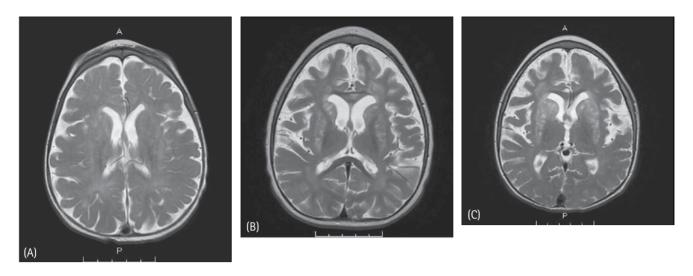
Magnetic resonance images (T2 signal) of JG: (A) at six months of age, (B) at three years of age, recently following an influenza A infection, (C) at three years and two months, after two months of treatment with metronidazole and N-acetylcysteine. Note progressive atrophy and encephalomalacia of putamen, caudate, lentiform nuclei, and periventricular white matter with cystic changes. The brainstem and cerebellum appeared normal.
